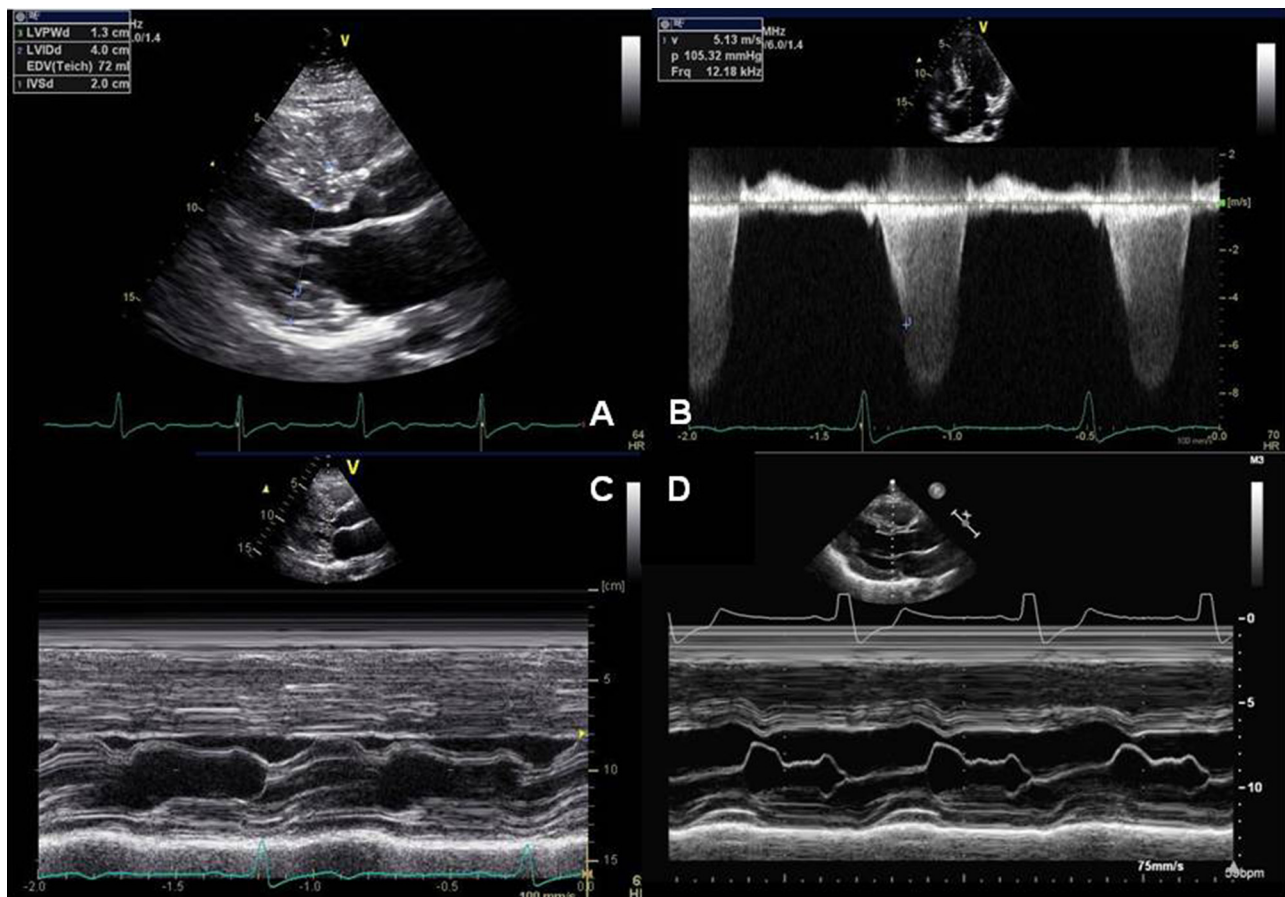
Echocardiographic assessment in hypertrophic cardiomyopathy (HCM). Parasternal long-axis showing asymmetric hypertrophy (A); continuous wave Doppler in a patient with obstructive HCM (B); M-mode of the left ventricle at the mitral valve level in a patient before (C) and after (D) a septal myectomy, demonstrating presence and absence of systolic anterior motion.
